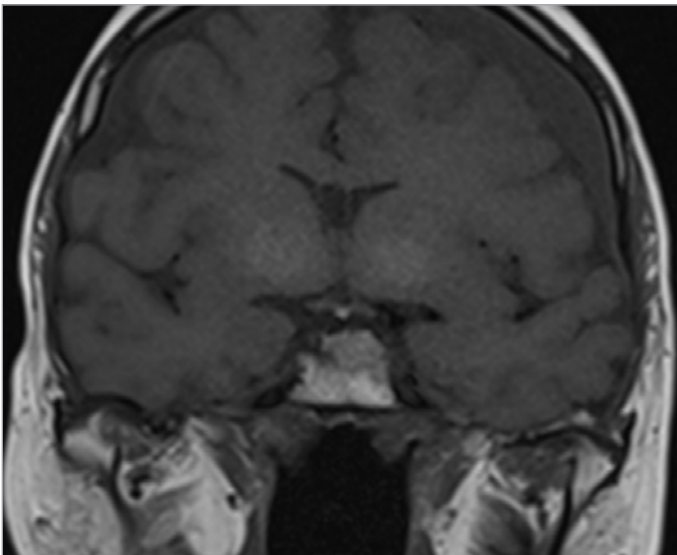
Hypophysis MRI coronal.
